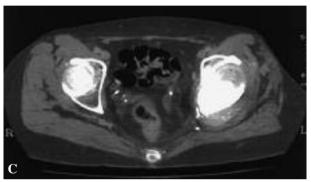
(A) Pelvic radiograph of a 48-year-old woman (Patient 5) showing a giant-cell tumour in the acetabular region (Region II). (B) CT scan showing the extension of the lesion in the acetabular region. (C) The computed tomographic scan done 10 months after surgery (curettage and filling of the cavity with PMMA) showed a local recurrence in both the iliac and ischial parts of the acetabulum.
